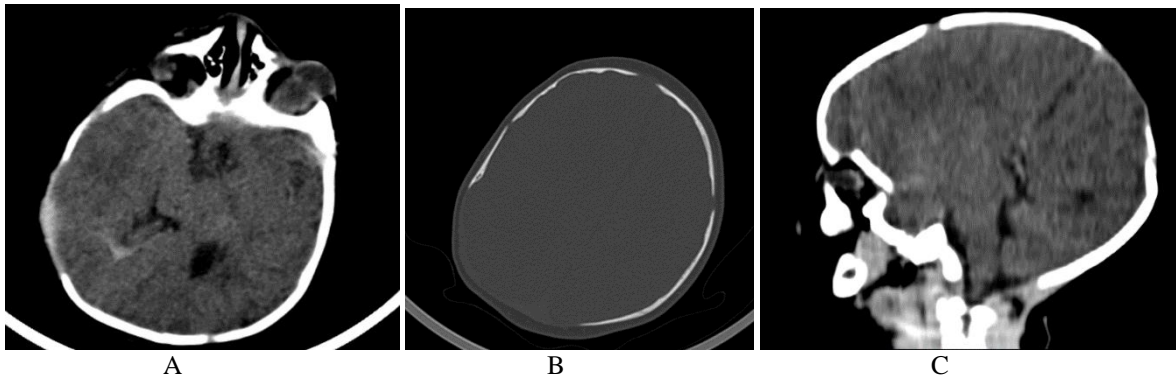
CT scan without contrast agent injection showing (A) right microphthalmia, left normal sized left eyeball connected with a cystic palpebral structure, (B) right occipital bone defect with widening of the sutures, (C) agenesis of the corpus callosum
